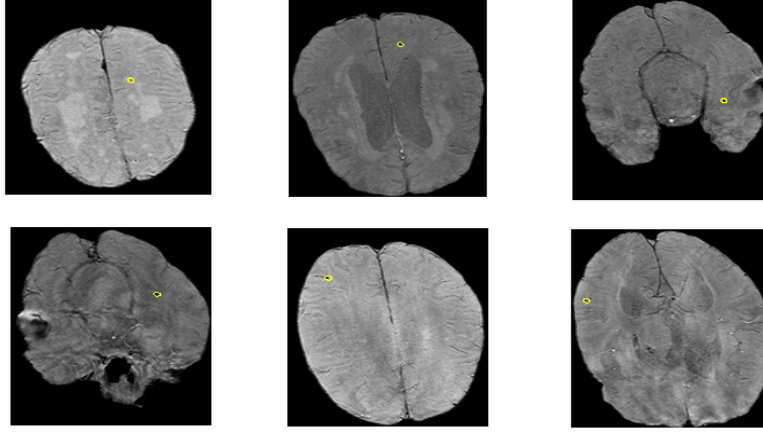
Some results of true-positives in T2* MRI images. The yellow circles indicate the location of the CMBs.
